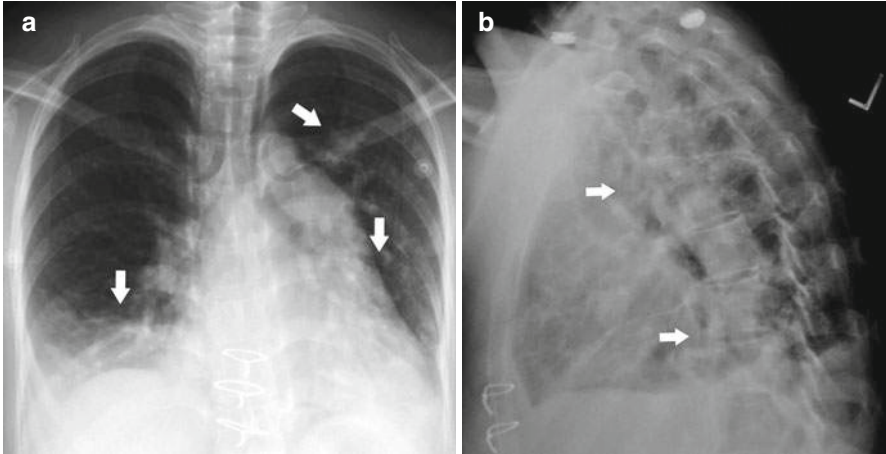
Pneumonia in a neutropenic patient. Chest X-ray posteroanterior (a) and lateral (b) views show multifocal pneumonia (*arrows*) bilaterally
